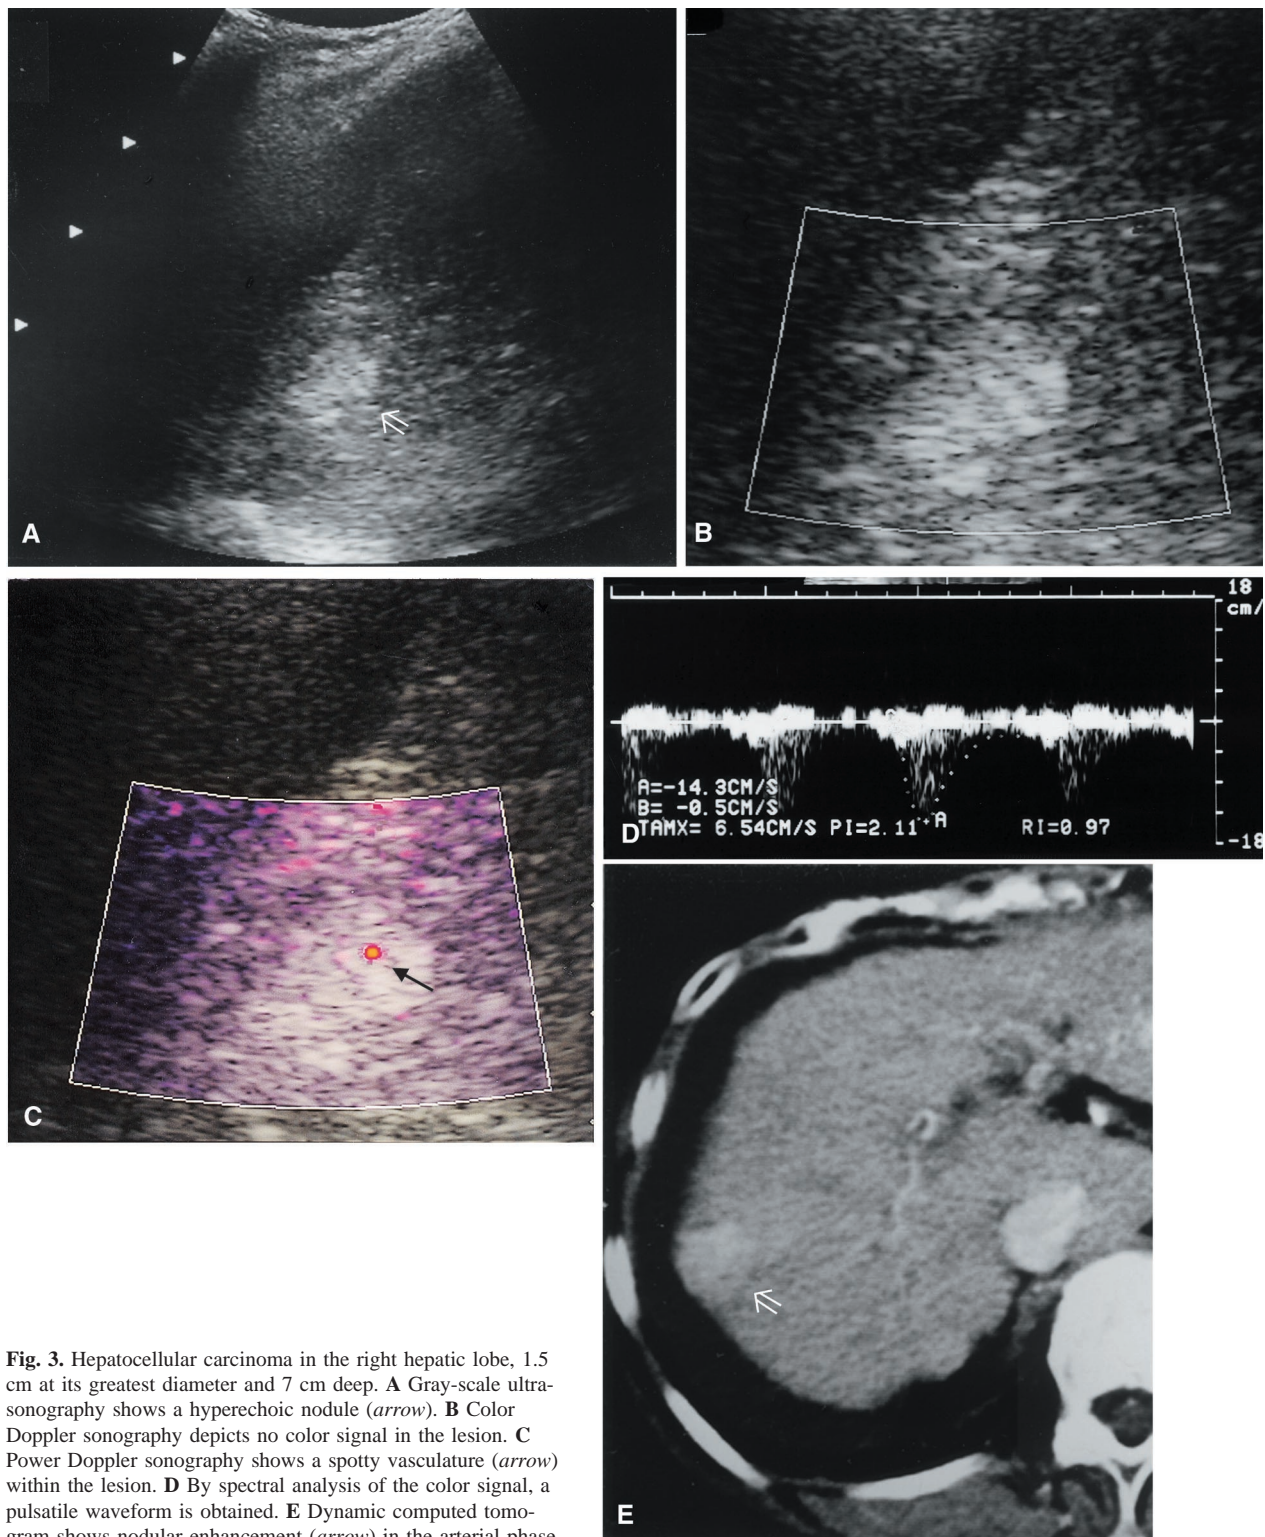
Hepatocellular carcinoma in the right hepatic lobe, 1.5 cm at its greatest diameter and 7 cm deep. A Gray-scale ultrasonography shows a hyperechoic nodule (*arrow*). B Color Doppler sonography depicts no color signal in the lesion. C Power Doppler sonography shows a spotty vasculature (*arrow*) within the lesion. D By spectral analysis of the color signal, a pulsatile waveform is obtained. E Dynamic computed tomogram shows nodular enhancement (*arrow*) in the arterial phase.
